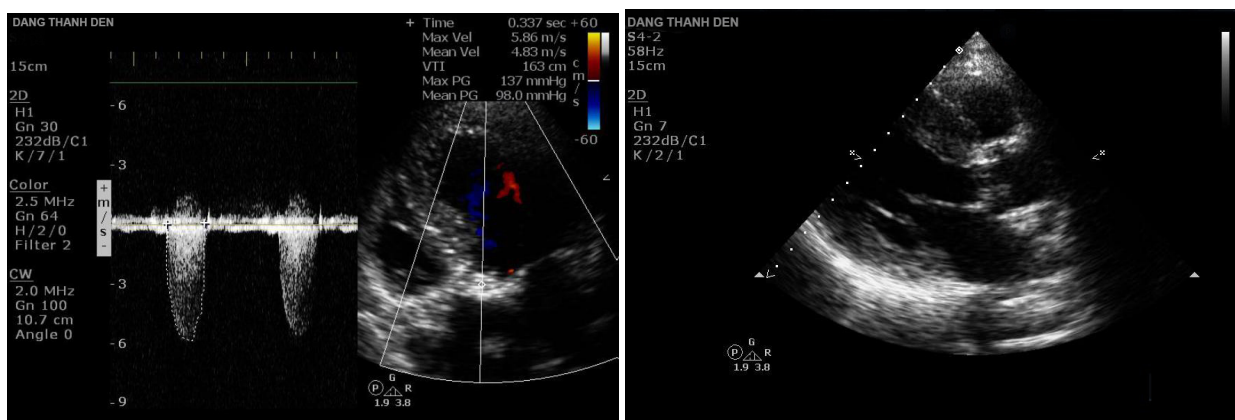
Echocardiography showed a critical calcified aortic stenosis
